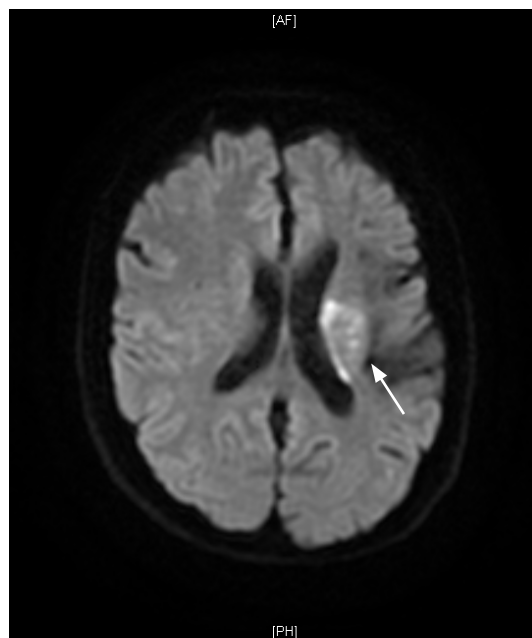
Magnetic resonance imaging DWI sequence showing restricted diffusion in the left corona radiata (arrow)
